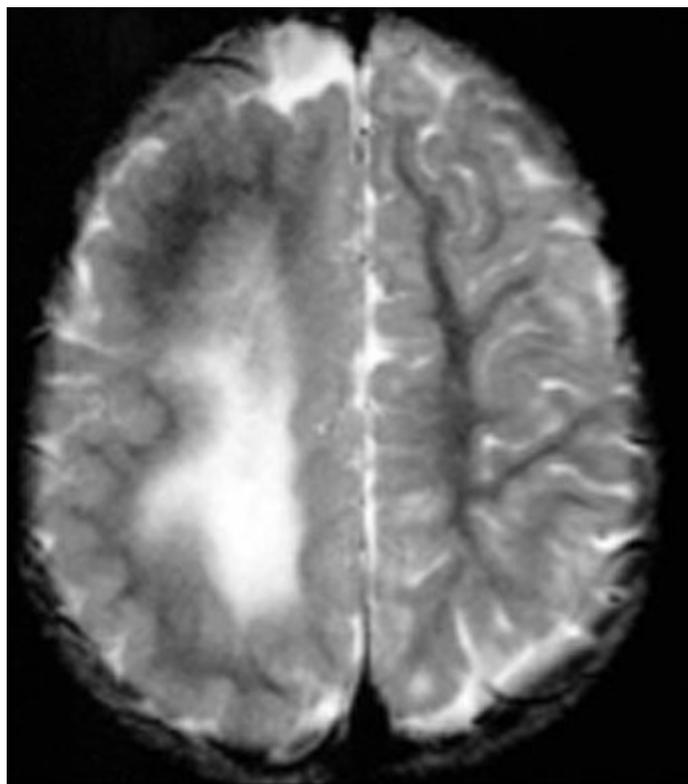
Hemimegalencephaly. Axial MRI shows large hemisphere with white matter changes. Note the smooth cortex in the posterior region.
